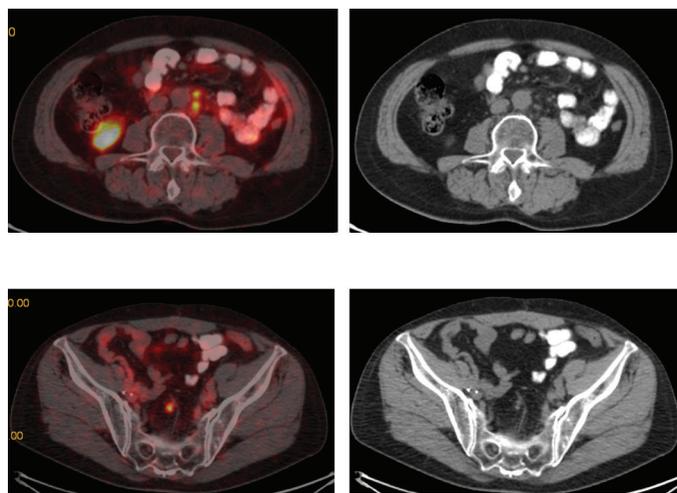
Millimetric lymph nodes in the paraaortic and presacral area in thoracoabdominopelvic CT of a 64-year-old patient who had pathology result of adenocarcinoma (Gleason 4+5) after radical prostatectomy and who developed PSA recurrence (tPSA=23.48 ng/mL) after radiotherapy. Ga-68 PSMA PET/CT showed intense pathological activity in these lymph nodes that did not reach the pathological dimension
